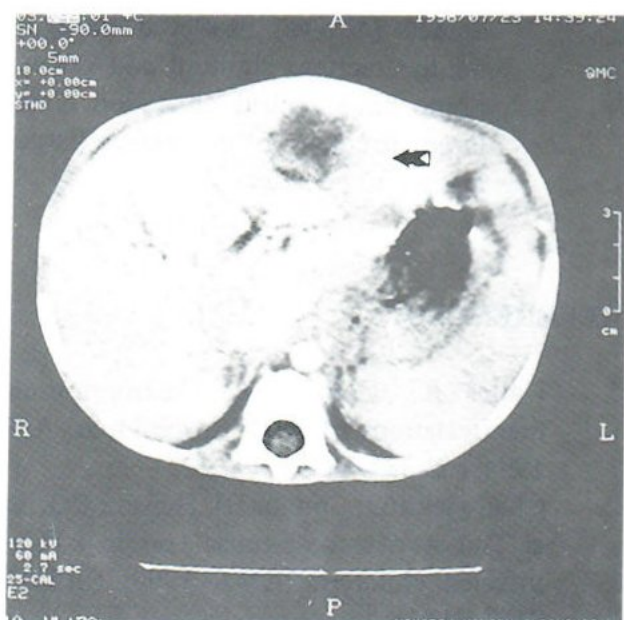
Follow-up CT scan with larger mass in left liver lobe (arrow). Note hypodense center.
